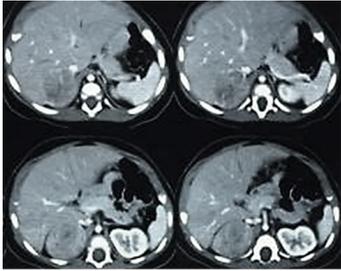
a: Contrast enhanced axial CT section of the upper abdomen reveals heterogeneously enhancing right adrenal lesion
